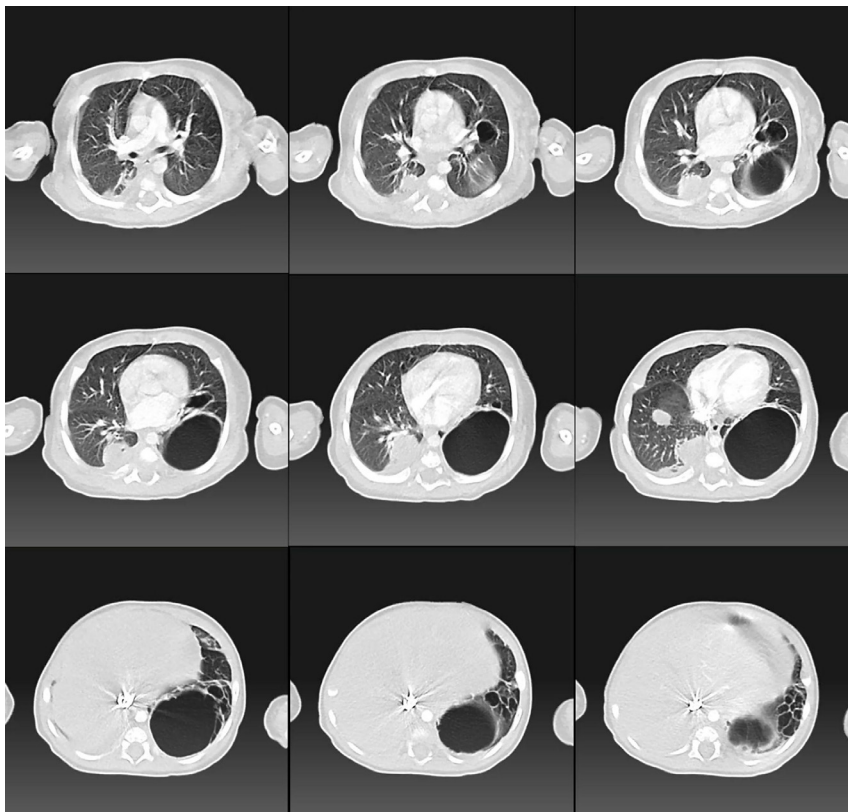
Chest computed tomography with contrast medium in axial slices showing CCAPM.
